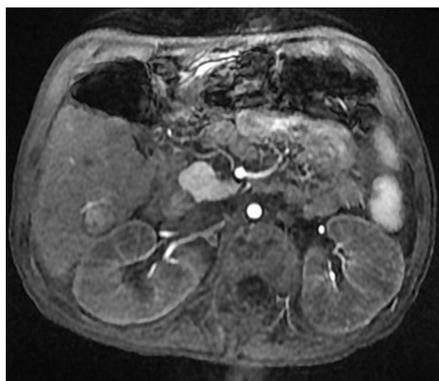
Magnetic resonance imaging of the liver with a large 1.5 cm × 1.6 cm lesion with arterial enhancement characterizing hepatocellular carcinoma and requiring chemoembolization.
